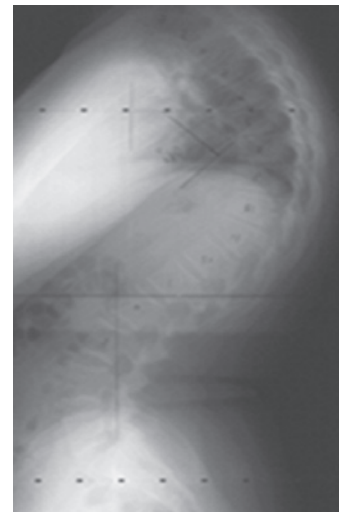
Radiograph of typical Scheuermann's kyphosis. Wedging of more than 5° in at least three adjacent vertebrae with vertebral endplate irregularities at the apex of the kyphosis is seen
